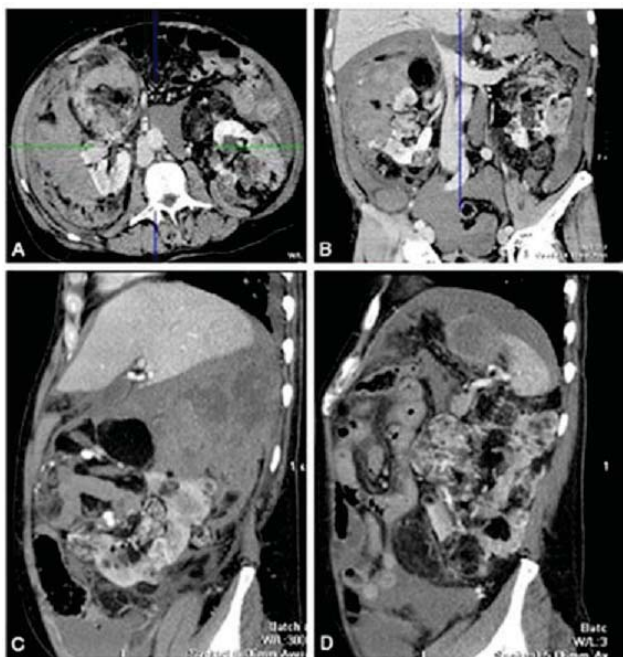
Postcontrast multiple detector computed tomography (MDCT): A) Sagittal and B) Coronal plane, show bilateral angiomyolipomas of the kidney with right sided retroperitoneal haemorrhage; C) Right sided kidney angiomyolipoma with haemorrhage; D) Left sided kidney angiomyolipoma.
